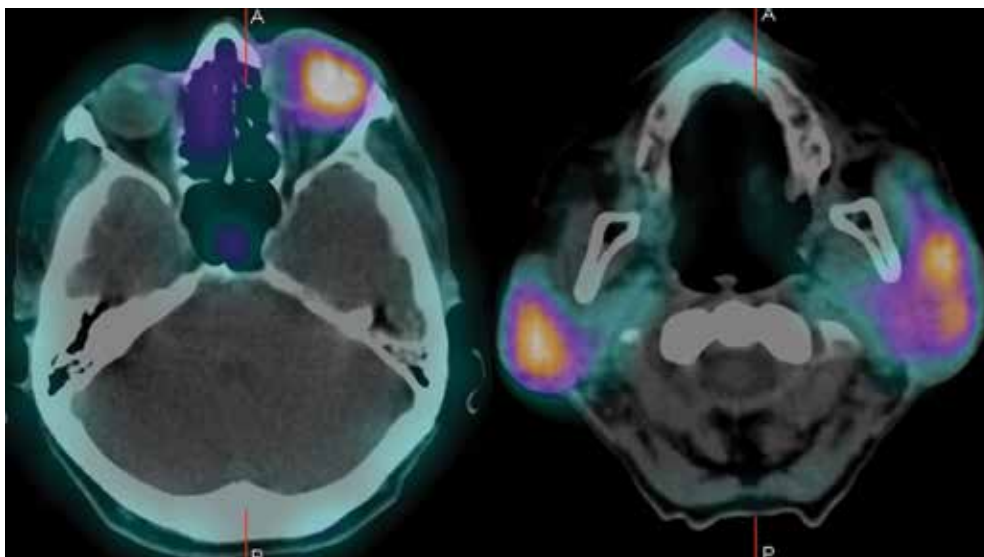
A 78-year-old female with NET G2 of lacrimal gland (case number 3). ^{99m}Tc -EDDA/HYNIC-TOC SPECT/CT was done as restaging. SPECT/CT images (axial view) revealed intensive uptake in left orbital cavity. SPECT/CT showed as well intensive uptake of the radiopharmaceutical in both parotid glands — Sjogren's syndrome. NET G2, neuroendocrine tumor grade 2; SPECT/CT, single photon emission computed tomography/computed tomography
